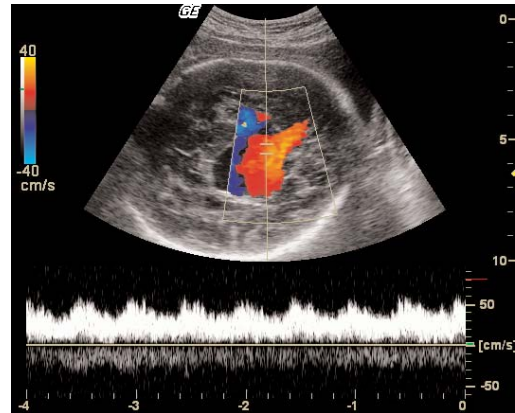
B mode colour doppler examination of the cranial structures in the antenatal period; vein of Galen aneurism and pulsatile character venous flow pattern in the midline.
